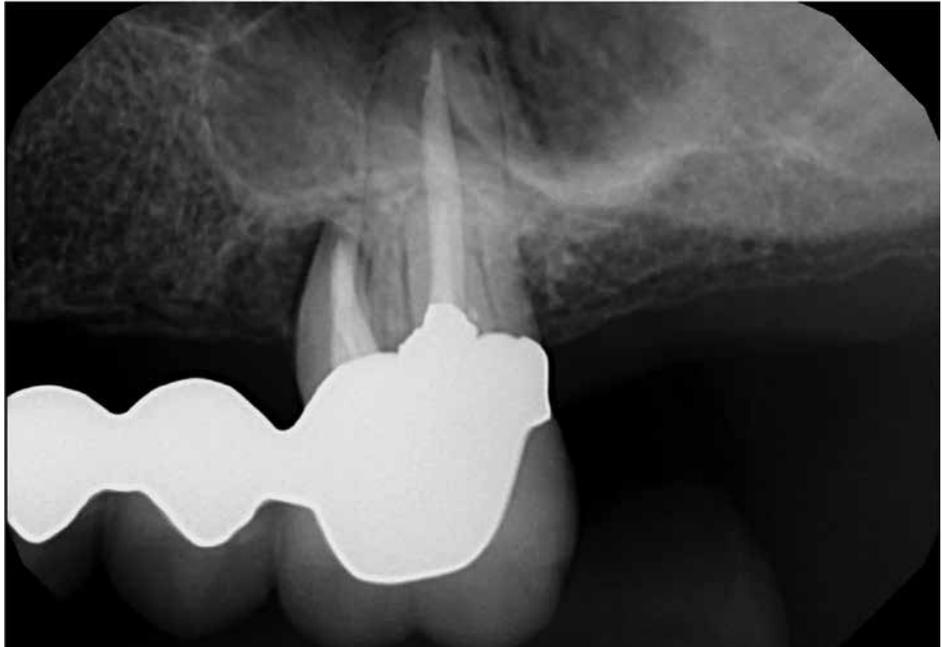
Preoperative radiograph showing bone loss around the mesial buccal root
